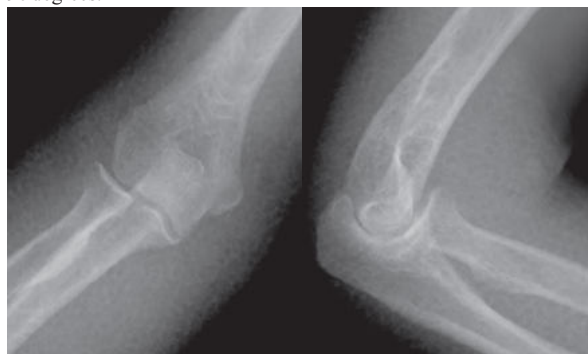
Post reduction radiographs revealed no fractures.
